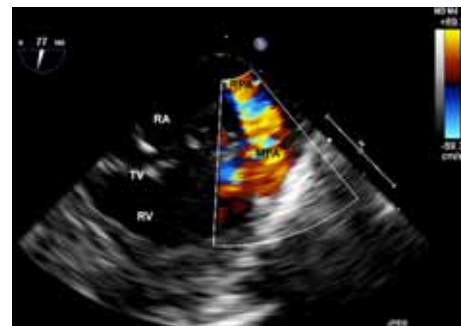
Color flow Doppler imaging of the right ventricular inflow – outflow view in a 2.5 kg patient who was undergoing surgery for a large membranous ventricular septal defect. MPA, main pulmonary artery; RA, right atrium; RPA, right pulmonary artery; RV, right ventricle.
